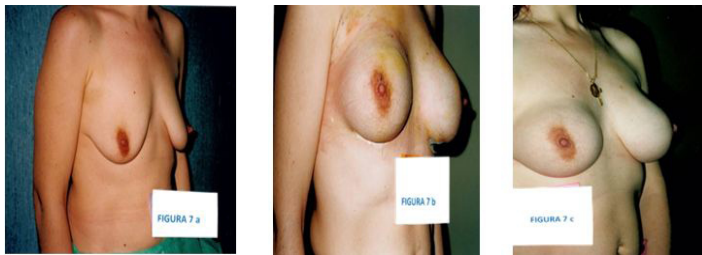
Photos of before (a) and four days after (b) and a few months after (c) in a case of Ultrasound assisted Mastopexy and augmentation with sub-glandular implants showing an obvious result from the first dressing at 4days.
